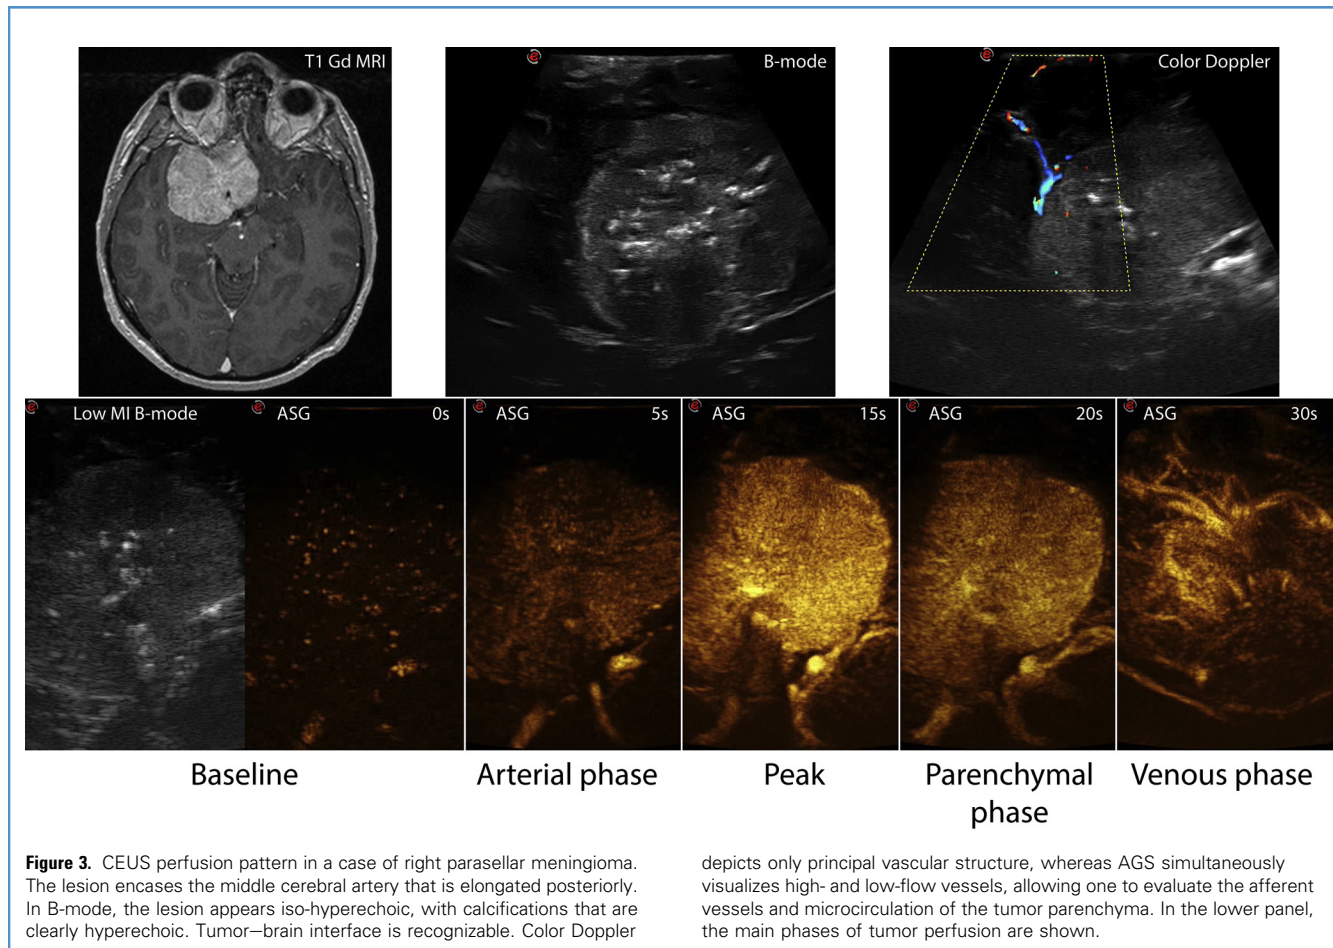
CEUS perfusion pattern in a case of right parasellar meningioma. The lesion encases the middle cerebral artery that is elongated posteriorly. In B-mode, the lesion appears iso-hyperechoic, with calcifications that are clearly hyperechoic. Tumor–brain interface is recognizable. Color Doppler
